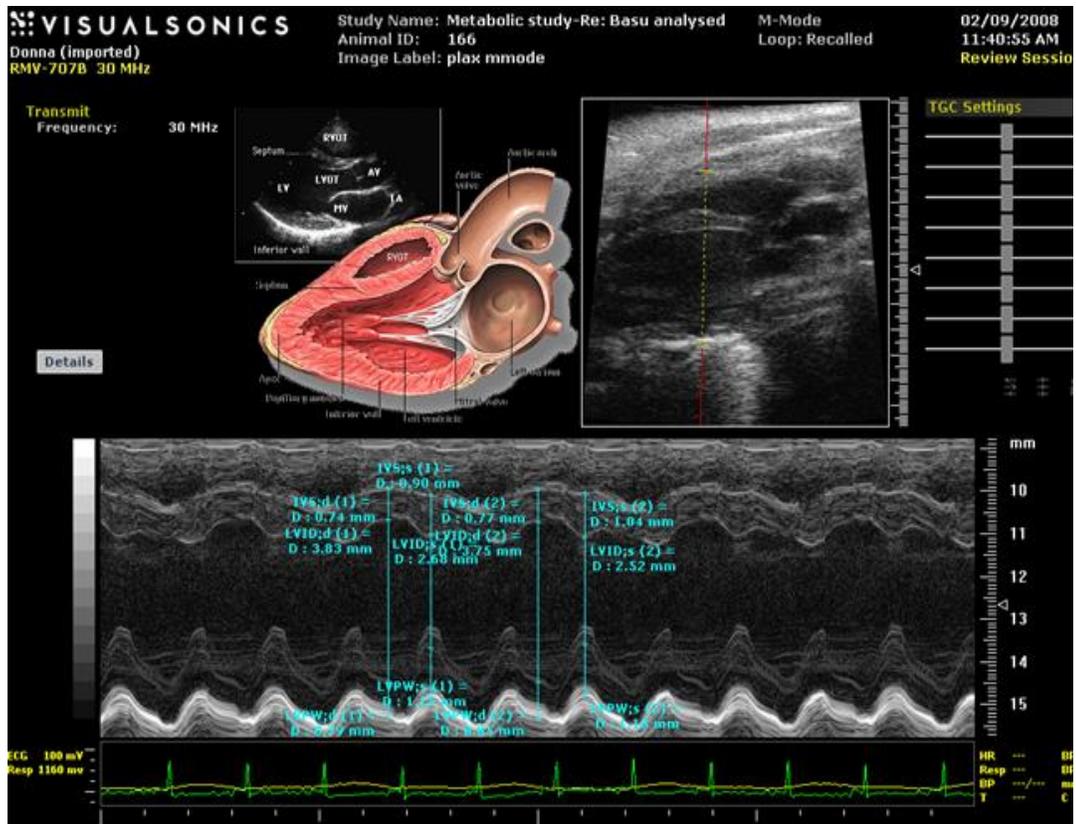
Echocardiogram M-mode imaging from parasternal long axis view for cardiac wall structure and systolic function assessment.
